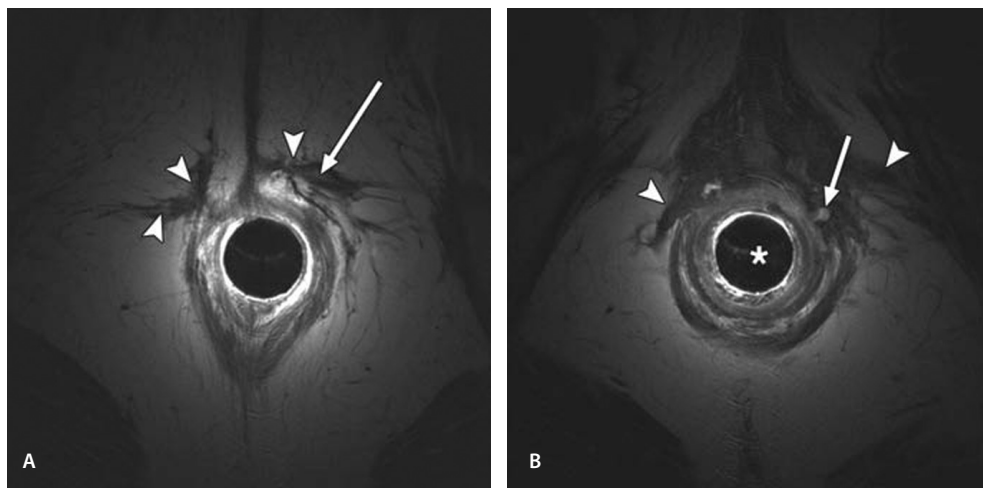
35-year-old woman with persistent anal and perianal pain after episiotomy and surgery for perianal fistula at another hospital 6 years earlier. Examination under general anesthesia revealed no obvious history of anorectal disease had significant abnormalities that could explain pain. A and B, Axial T2-weighted images through lower external anal sphincter (A) and at more proximal level (B) show extensive scarring (arrowheads) of anterior aspect of external anal sphincter and perineum and active small fistula (arrows) in scar tissue. Surgery revealed trans-sphincteric fistula. Asterisk indicates endoluminal coil in anal canal.
